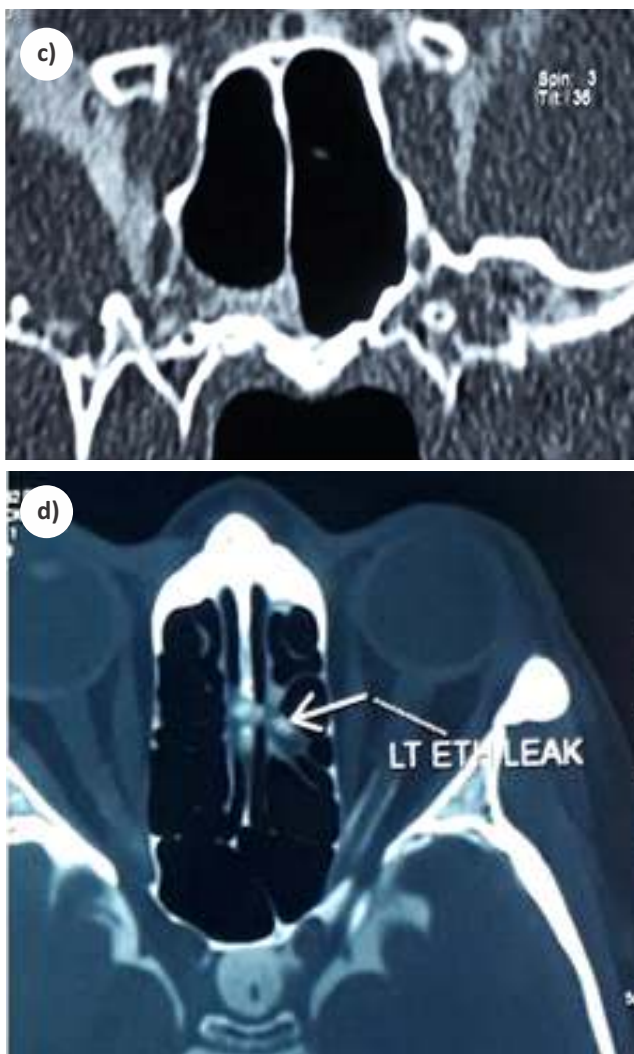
(c) HRCT nose and paranasal sinuses showing defect in the right anterior and inferior aspect of the lateral wall of sphenoid and (d) HRCT nose and paranasal sinuses axial view showing defect in the left roof of ethmoid.
